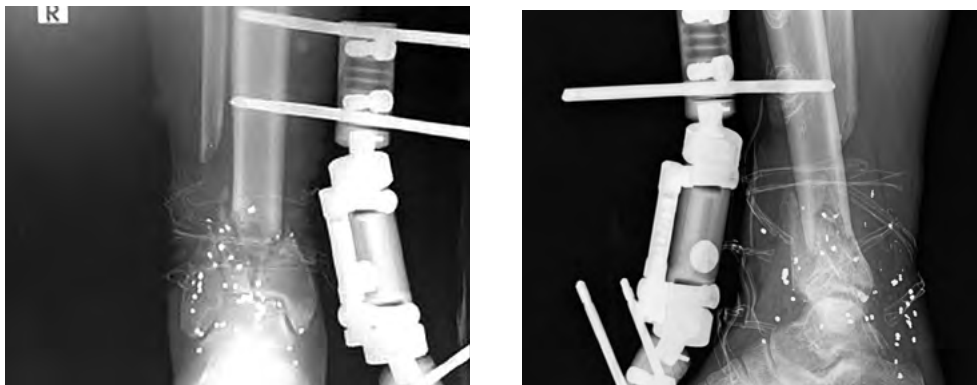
Postoperative plain radiographs. An external fixator was placed. 1 month post-op. Anteroposterior (AP) and Lateral views of the right lower leg/ankle (A and B)
